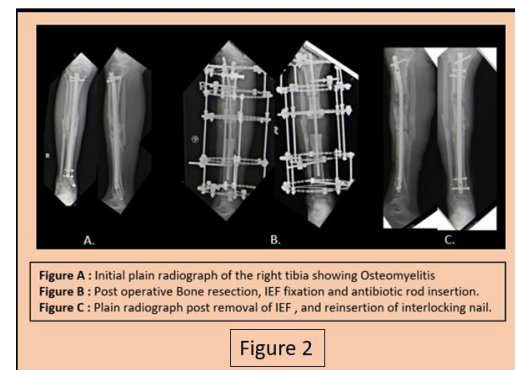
Plain radiograph of the right tibia pre operatively and post operatively
